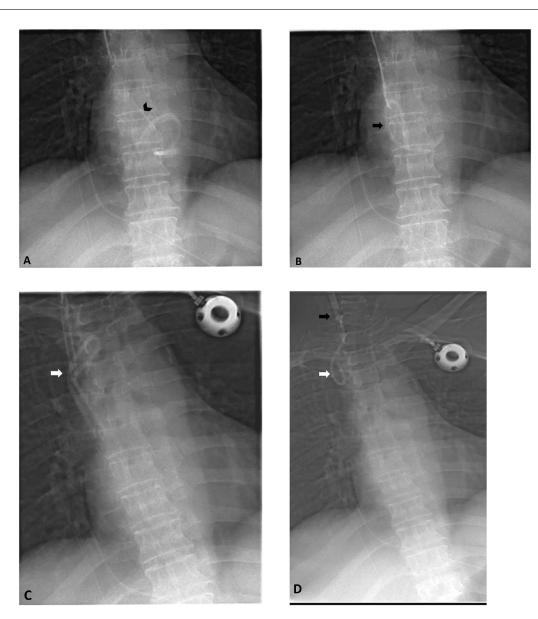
(A–D) Spot intra-procedure X-ray images showing step by step retrieval of broken port-a-catheter from right heart with manual snare by using combination of 4 Fr Renal Double Curve (RDC) catheter and 0.014-BMW guide wire. (A) showing successful grasp of broken port-a-catheter in snare loop (black arrowhead). (B) showing retrieval of broken catheter in to right atrium (black arrow). (C) showing further proximal retrieval of broken catheter in to SVC (white arrow). (D) showing successful negotiation of broken catheter (white arrow) in to vascular access sheath placed in right IJV (black arrow).
